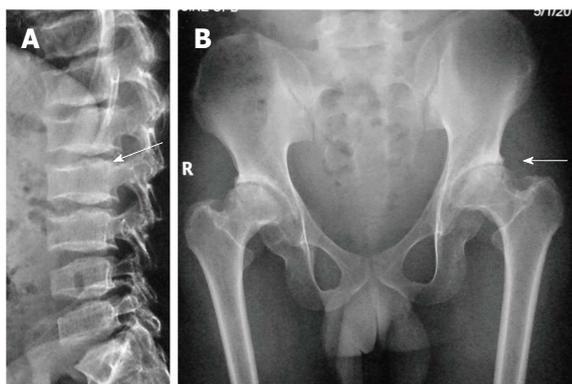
Spondyloepiphyseal dysplasia tarda. Lateral radiograph of lumbar spine (A) shows characteristic posterior hump (arrow). Radiograph of pelvis (B) shows bilateral flattened femoral heads, short necks and premature degenerative changes (arrow).
